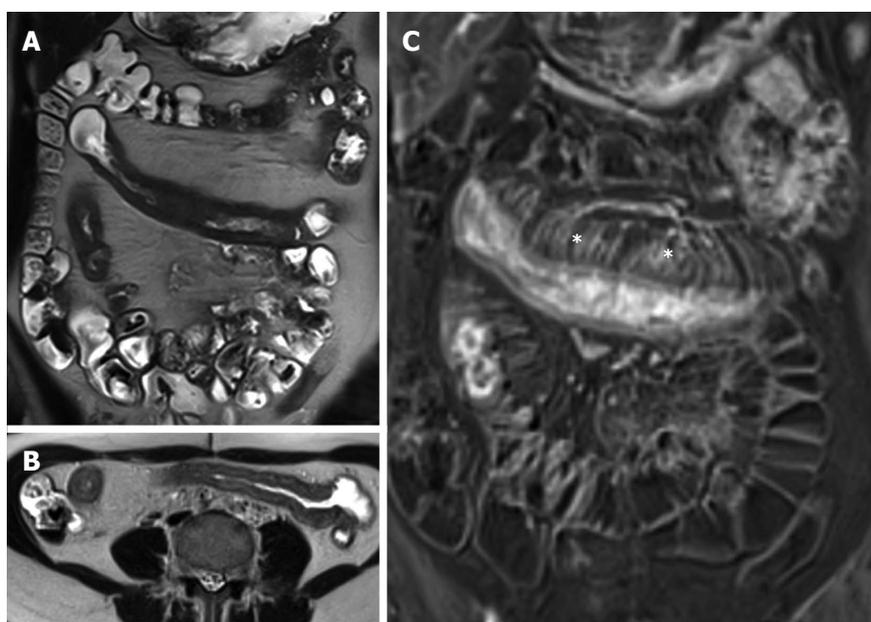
Thirteen years old female with active Crohn's disease. Coronal (A), transverse (B) T2-weighted images show thickened, inflamed segments of ileum and fat proliferating in the mesentery. The thin layer of high signal on T2 in b represents edema. The mass of the fat will displace adjacent small bowel. Coronal post-contrast T1-weighted fat-suppressed image (C) shows increased vascularity (asterisks), named "comb sign", adjacent to a hyper-enhancing thickened segment of ileum.
